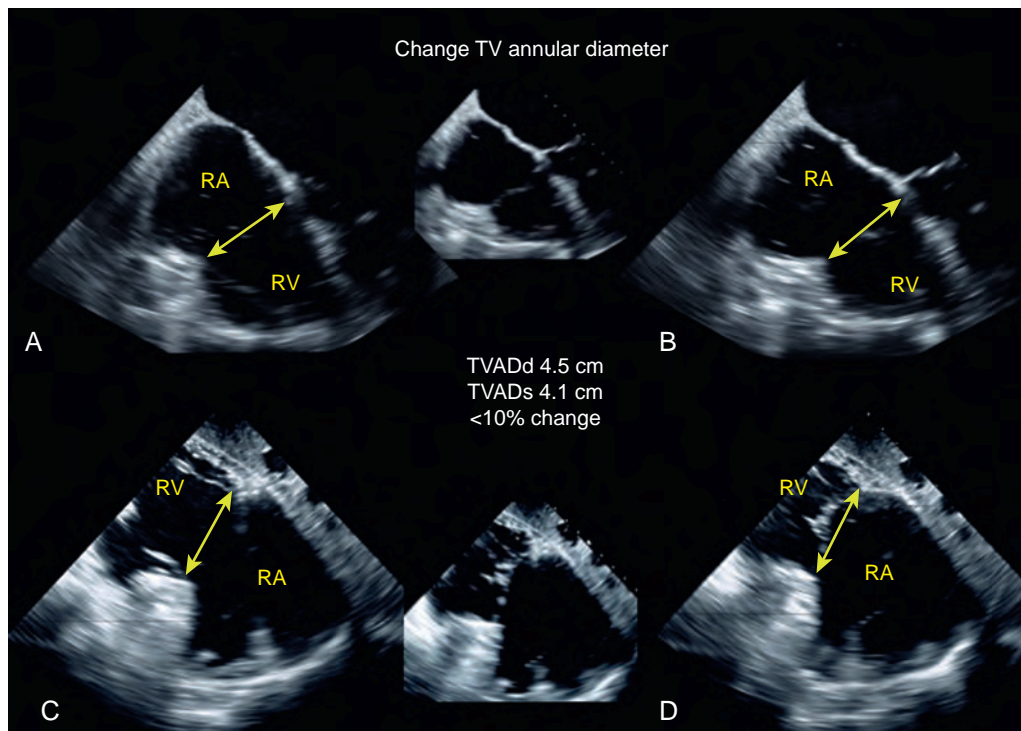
Assessment of tricuspid annular changes. Using two echocardiographic windows, the change in tricuspid valve annular diameter (TVAD) is assessed during the cardiac cycle to help determine reversibility of tricuspid regurgitation (TR) in helping to determine whether or not a repair should be considered. (A) and (B) Midesophageal four-chamber views. (C) and (D) Transgastric views. A change less than 10% supports performing tricuspid valve surgery if TR is present. RA, Right atrium; RV, right ventricle.
